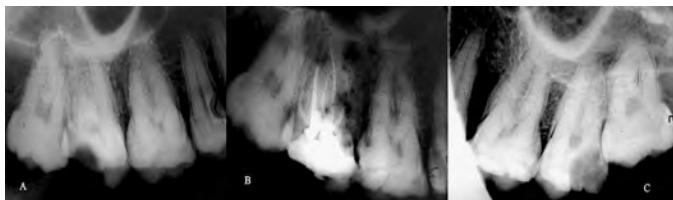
(Left) Pre-operative diagnostic radiograph suggesting the presence of extra palatal root canal on the maxillary left second molar. (Center) Post-obturation radiograph confirming the presence of the extra palatal root canal on the maxillary left second molar. (Right) Radiograph of the maxillary right second molar showing only one palatal root canal. Case is a 22 year old female.
